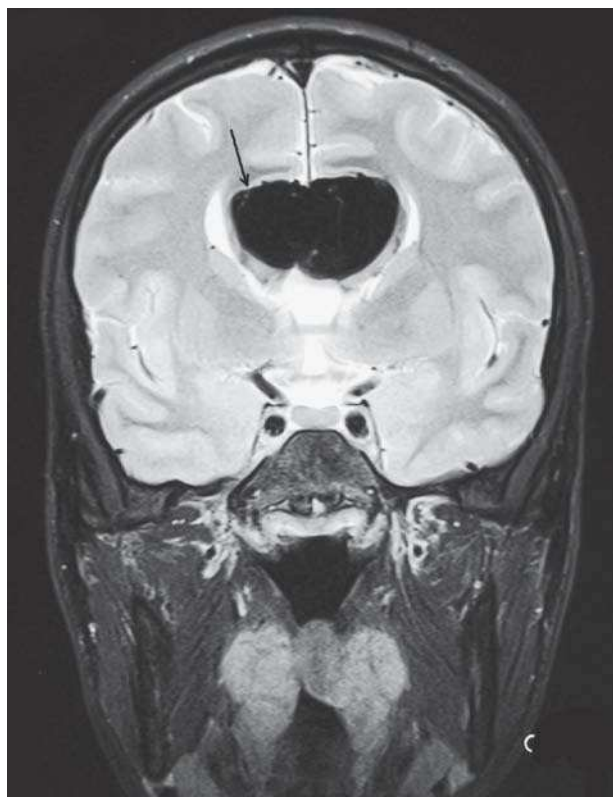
Fat-suppressed T2-weighted MRI, in coronal plane.
